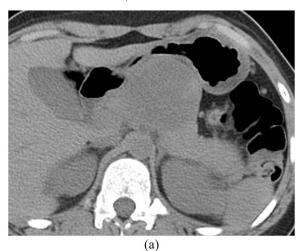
Solid pseudopapillary tumour of the pancreas in a 63-year-old male. (a) Axial CT scan obtained during the pancreatic phase shows a completely solid poorly enhancing mass at the pancreas head. (b) Coronal multiplanar reconstruction image of the portal venous phase shows a lobulated shape mass (arrows) with heterogeneous enhancement.
